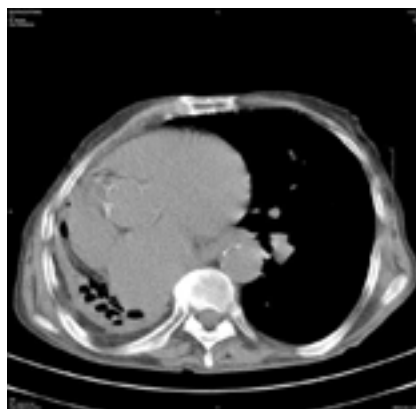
Chest computed tomography without contrast in 12-month of pleurodesis shows that in addition to right-sided destroyed lung, full expansion of left lung and slight pleural thickening in costodiaphragmatic angle
